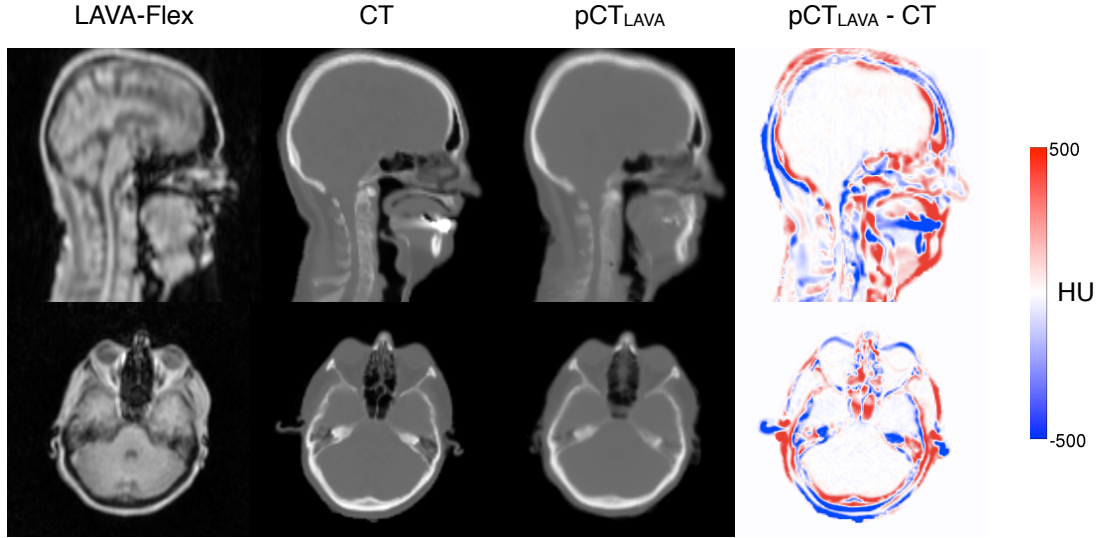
For a representative subject, the LAVA-Flex image, the reference CT, the pseudo CT synthesised from the LAVA-Flex image, and the difference image between the pseudo CT and the reference CT.
